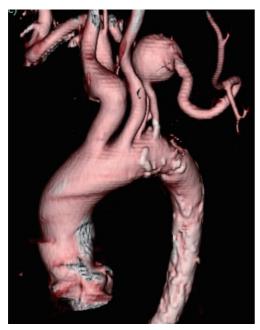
Preoperative three-dimensional computed tomography angiogram of case 1.
